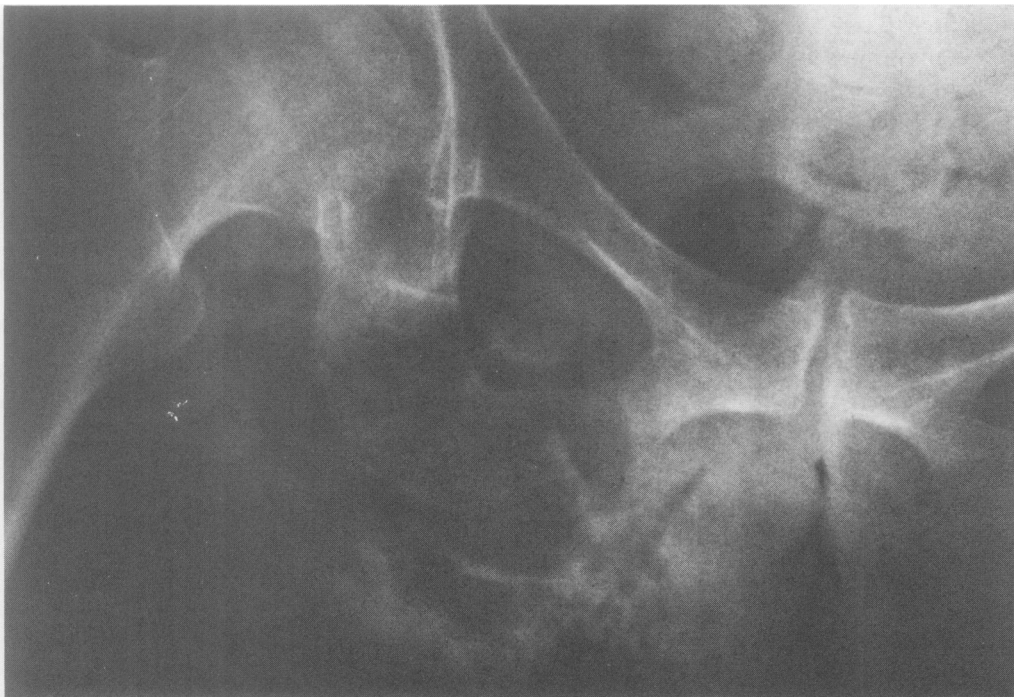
X-ray of the lesion in patient 2 on admission. The presence of subcutaneous emphysema should alert the physician to ruptured bowel communicating with the subcutaneous tissues.
